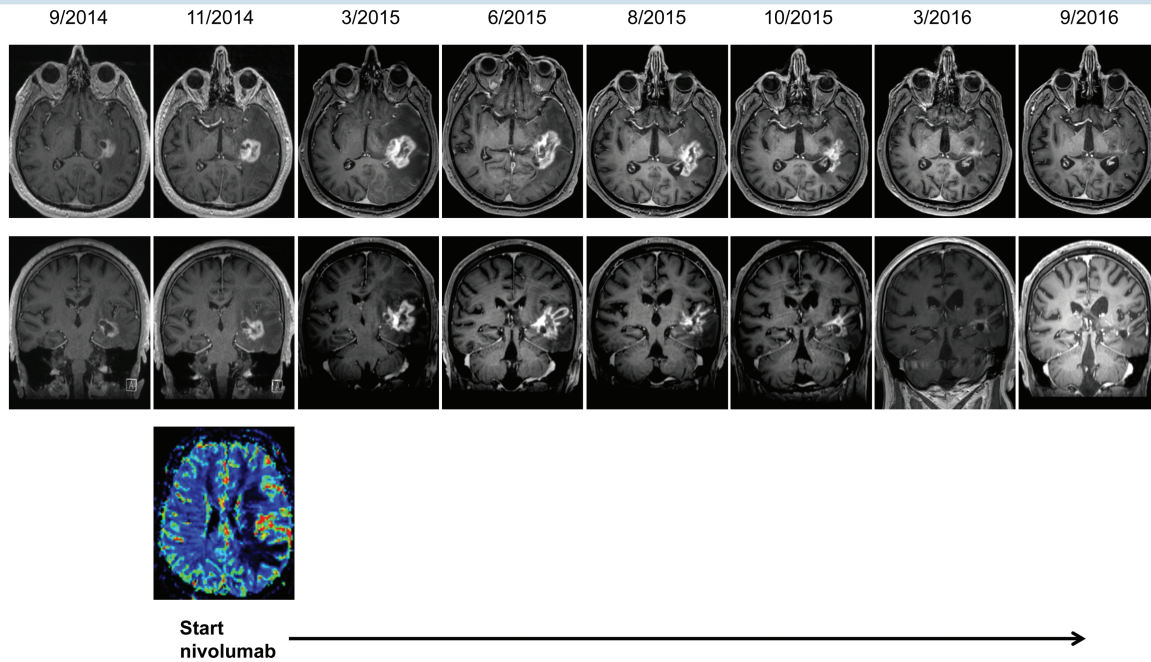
T1-weighted contrast-enhanced MRI showing stable disease during (9/2014) and tumor progression after 6 cycles of maintenance temozolomide (11/2014). Tumor progression was confirmed by MR perfusion (bottom). The MRI scan 3 months after initiation of nivolumab treatment (3/2015) demonstrates increased contrast enhancement and pronounced edema. Subsequent MRI scans during ongoing nivolumab treatment indicate partial remission and durable tumor control.
